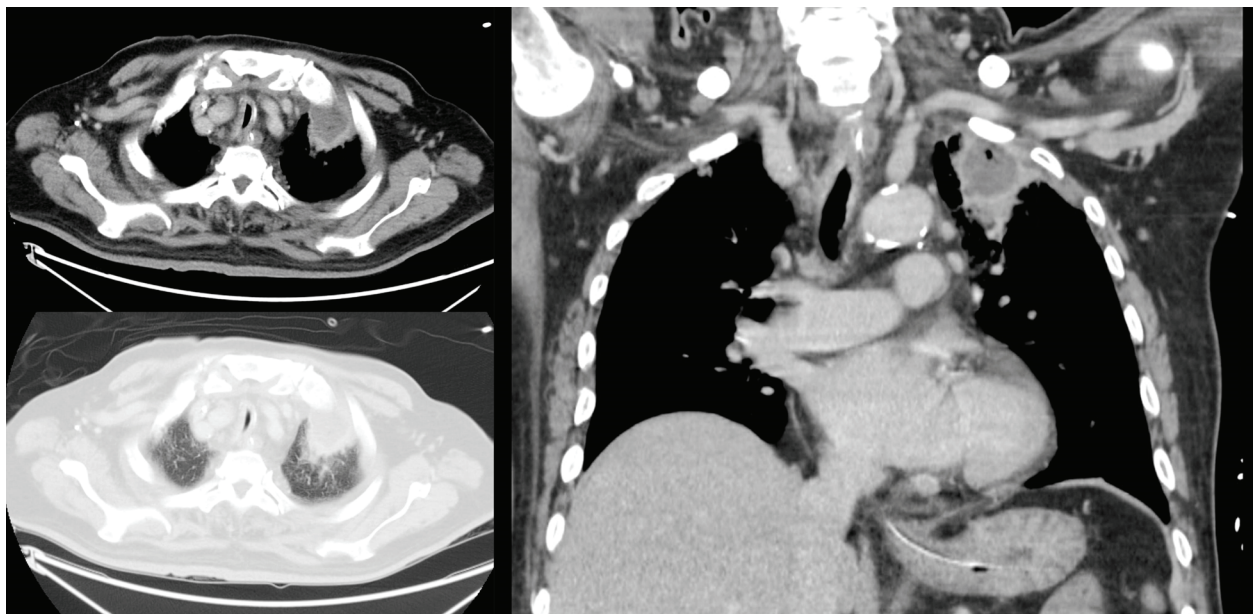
CT of the chest revealed a mass lesion at the LUL, measuring 5.7cm in diameter with internal low attenuating necrosis and focal air-densities. Also, a small amount of left-sided pleural effusion was found.
